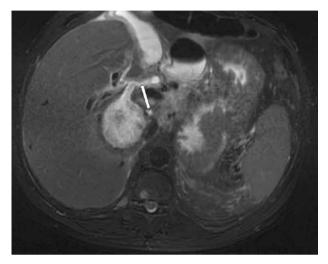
MRI of a fistula between the echinococcal cyst and the biliary tract. Axial fat-suppressed T2-weighted image shows the cystic lesion as demonstrated on the CT. A communicating tract is observed between the lesion and the right hepatic duct (arrow).
